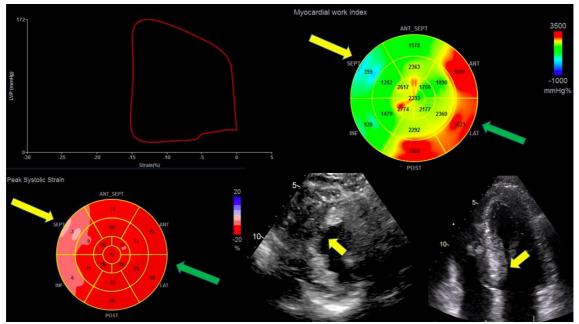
Example of Myocardial Work (MW) estimation in a patient with obstructive hypertrophic cardiomyopathy. At the bull's eye in the high right panel evidence of reduced MW at the septum (blue segment), corresponding to the same area of low myocardial strain as shown in the bull's eye in the lower left panel, and to the more hypertrophic area as shown at transthoracic echocardiography (yellow small arrows). As indicated by the green arrows, evidence of high work at posterior, anterior and lateral segments (red segments at bull's eye in the high right panel), corresponding to the same area with preserved myocardial strain (green arrow at the lower left panel).
